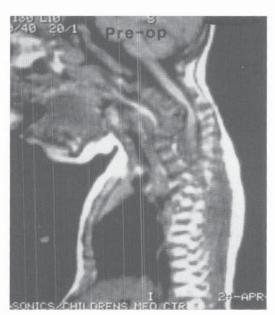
A, Lateral radiograph of a 10-month-old infant with Larsen's syndrome. B, MR image showing cord impingement and narrowing.
